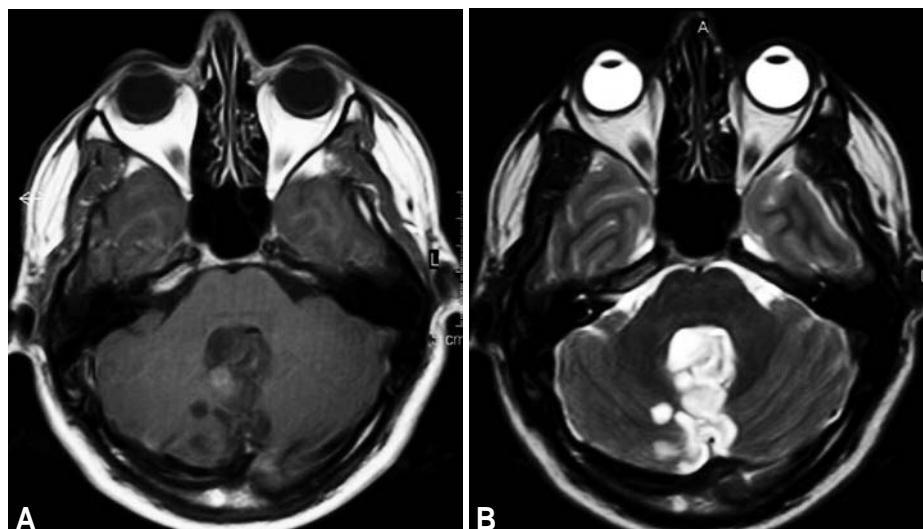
A T1-weighted MR imaging shows low intensity of the tumour mass and focal gadolinium enhancement. B T2-weighted imaging demonstrates a relatively hyperintense, midline tumour, occupying the fourth ventricle and involving cerebellar vermis.
